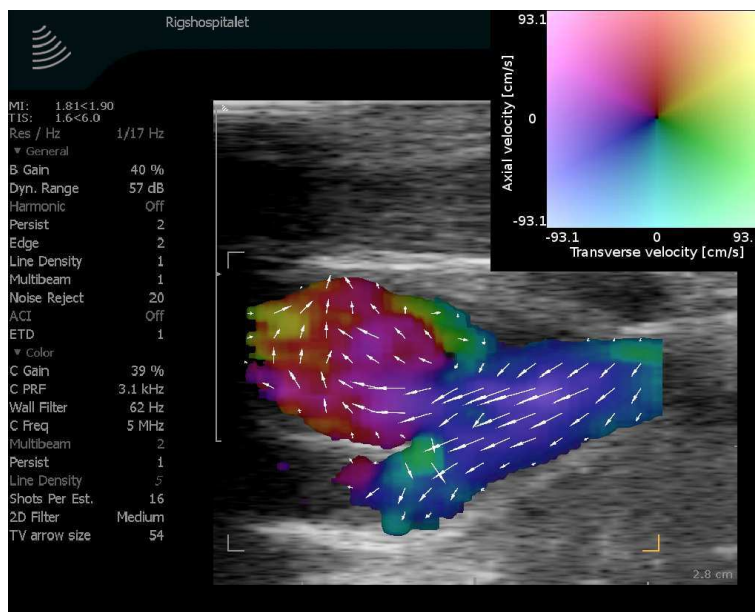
Ultrasound scanning with vector flow of the carotid bifurcation. The complex flow in the carotid bulb (top left) is visible and detailed vector information can be used to quantify the complexity of the flow.*
